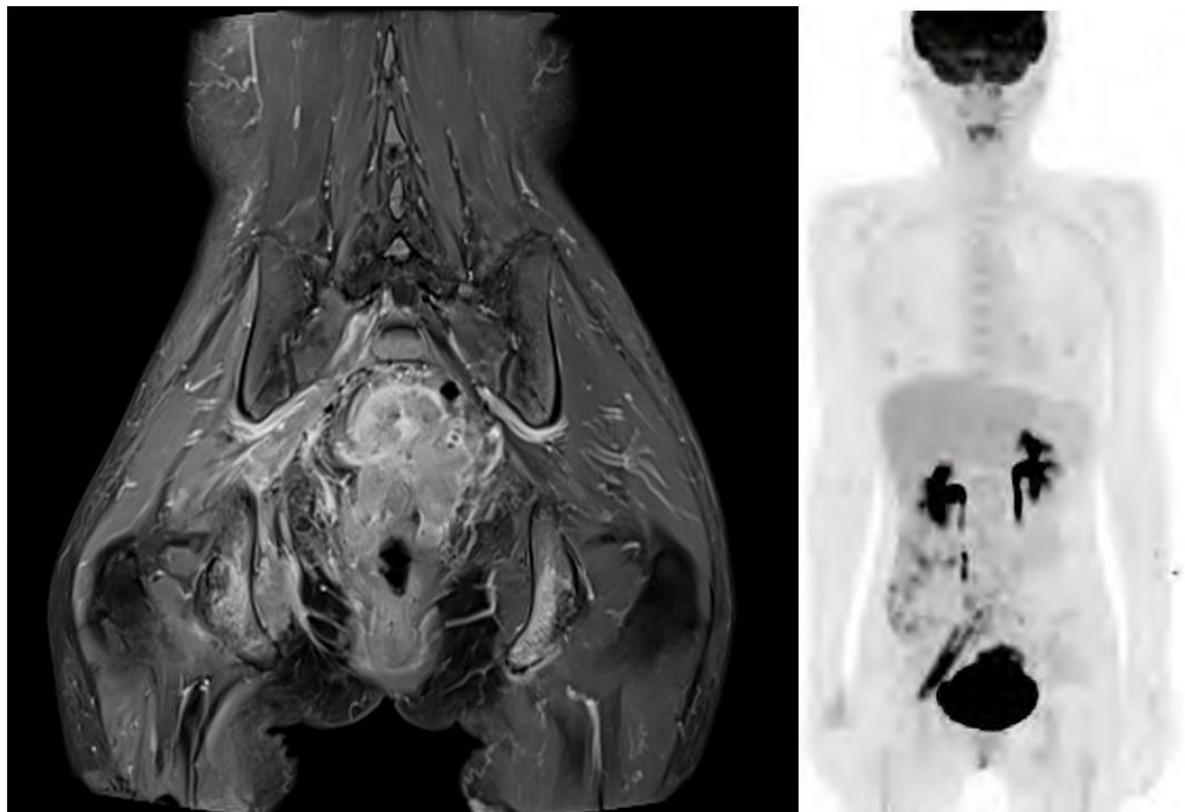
MRI (T1-weighted) and FDG PET/CT image of neural invasion by cervical cancer. The right lumbosacral plexus is obviously enlarged with low-signal mass on MRI. Linearly increased FDG uptake is found in the right pelvis on PET/CT. Correlating these image findings, neoplastic lumbosacral plexopathy is suspected.
